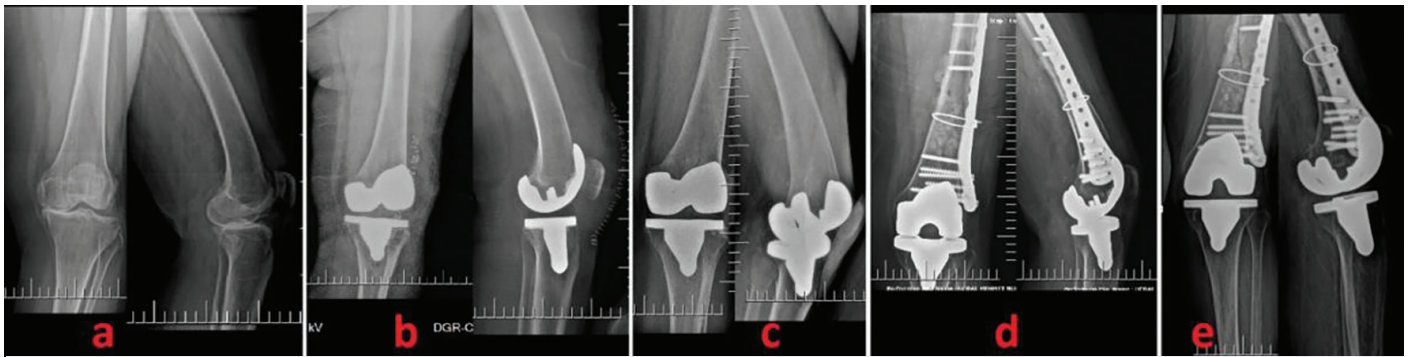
a) Eighty year old women with grade 4 arthritis b) Postoperative X-rays c) 46 months follow-up d) At 56 month periprosthetic fracture occurred and treated accordingly e) 89 month follow-up
